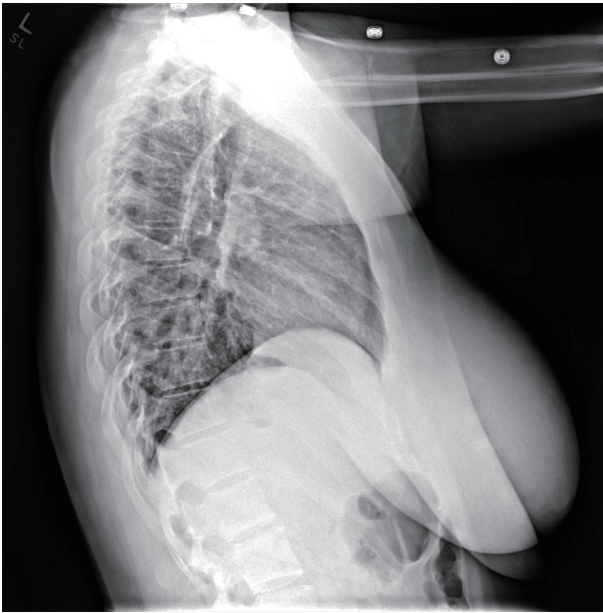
Lateral chest X-ray from second emergency department visit 2 days later.
